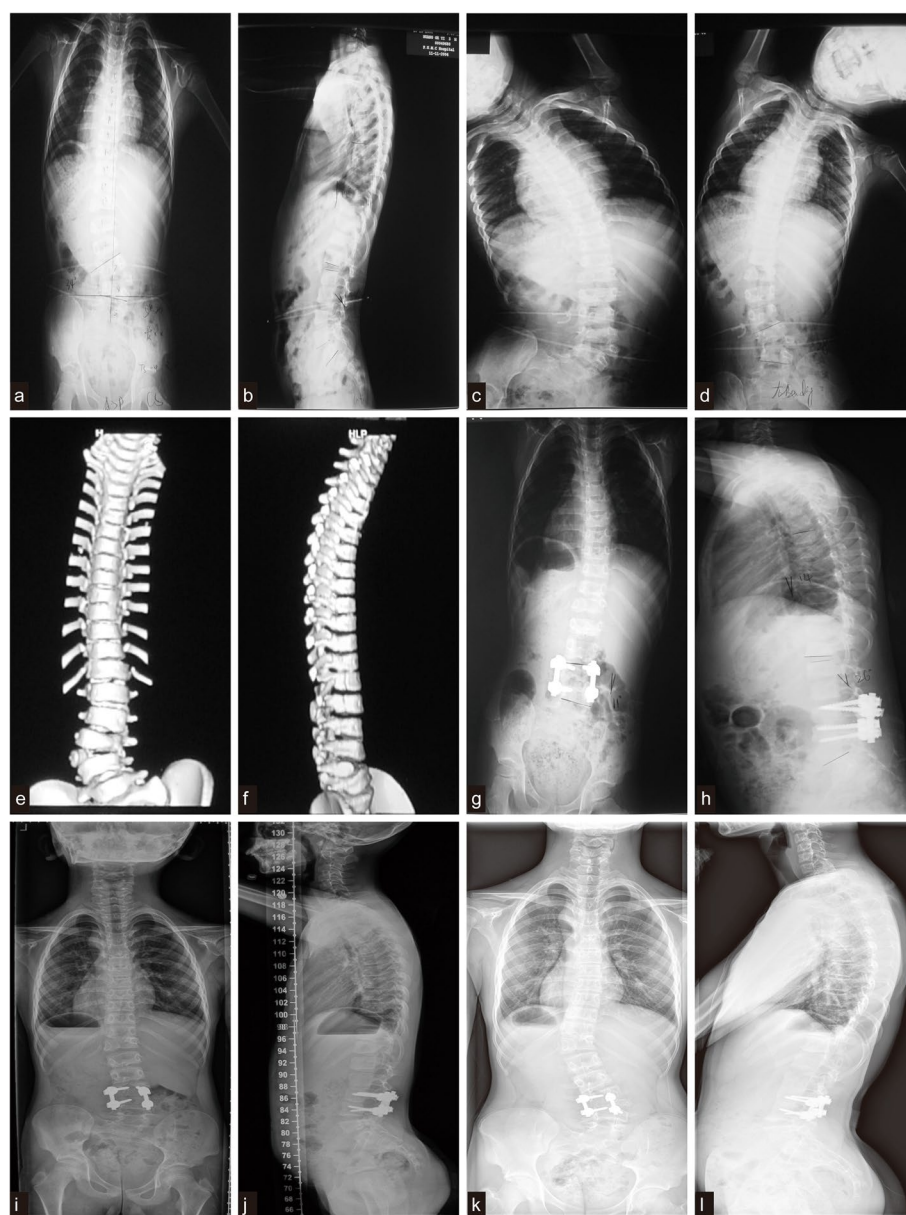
A 4-year-old male patient presenting with scoliosis resulting from a fully segmented hemivertebra located between the right L3 and L4 vertebrae. a Preoperative posteroanterior standing X-ray at the age of 4, displaying lumbar scoliosis accompanied by compensatory curvature. b Preoperative lateral radiograph. c,d Lateral bending radiograph in the supine position, also referred to as the left and right bending views. e,f Preoperative three-dimensional CT reconstruction images. g Postoperative posteroanterior standing radiograph taken immediately after surgery. h Immediate postoperative lateral radiograph following the posterior resection of the L3/4 hemivertebra, accompanied by L3-L4 instrumentation and fusion. i Posteroanterior standing X-ray taken five years after the surgery. j Lateral X-ray image obtained five years following surgery. k The posteroanterior standing radiograph taken 11 years after surgery reveals the occurrence of a crankshaft phenomenon, which is being monitored during follow-up. l Lateral X-ray image taken 11 years following the surgery
